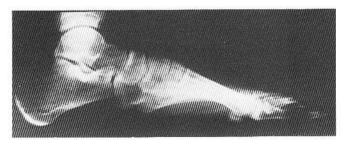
A low calcaneal inclination angle is seen in this pronated foot x-ray.
